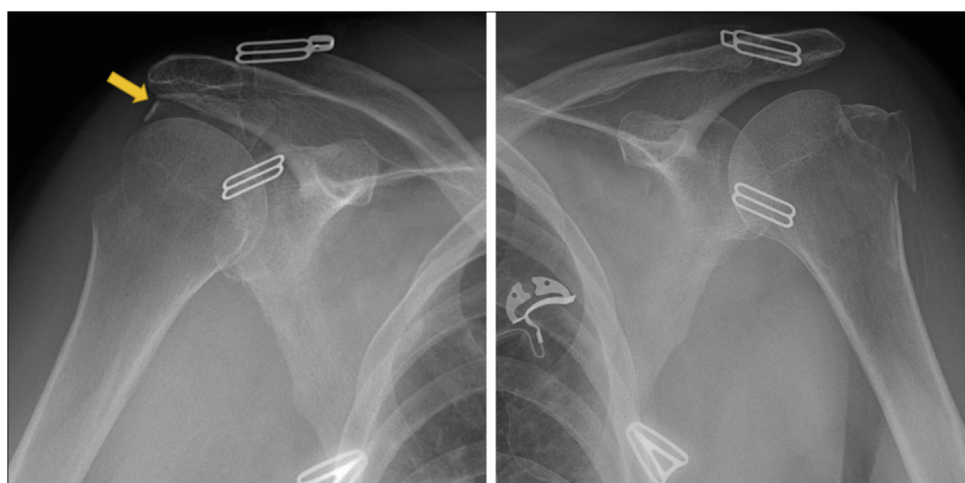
Postreduction radiographs. Significant medial and proximal displacement of the right greater tuberosity (yellow arrow).
